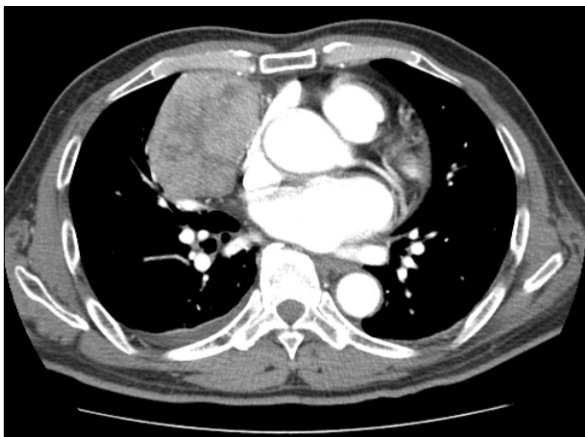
Contrast enhanced chest CT shows 7.3×5.3 cm, oval shape, well-defined mass within anterior mediastinum. The mass shows heterogeneous enhancement without evidence of invasion through capsule or involvement of nearby structures.
